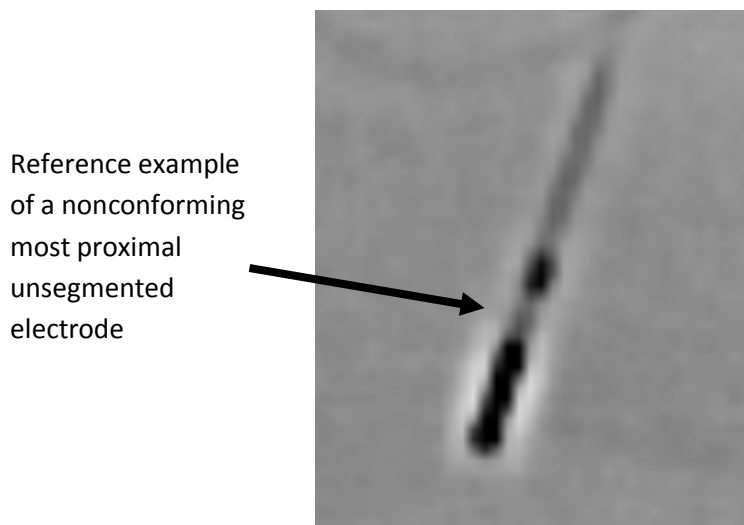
shows an example of a fluoroscopic Anterior Posterior X-ray of a nonconforming lead and a conforming lead
